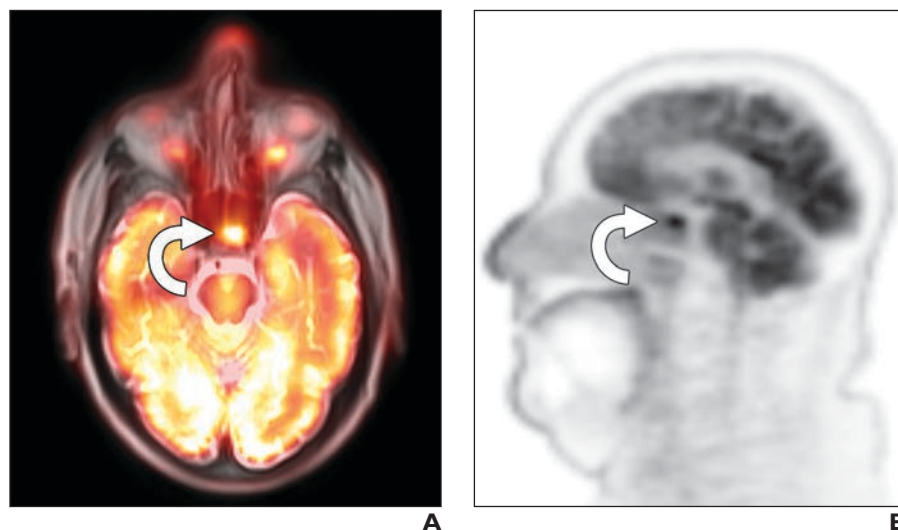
79-year-old man with head and neck cancer. A and B, PET/MRI axial fusion image with T1-weighted radial volumetric interpolated breath-hold examination fat suppression image (A) and PET sagittal image (B) show intense hypermetabolic focus representing pituitary adenoma (arrows).
